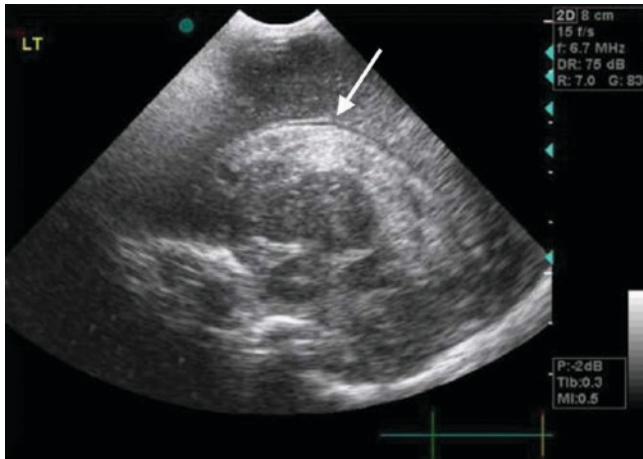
Grade 3 intraventricular haemorrhage. Parasagittal ultrasound image demonstrates hyperechoic blood (arrow) within a dilated left lateral ventricle
